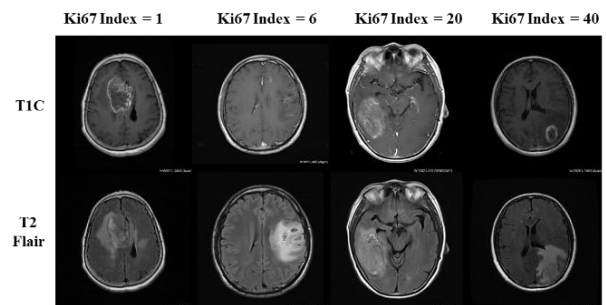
The multi-modal MRI images of patients with different Ki67 indexes.
